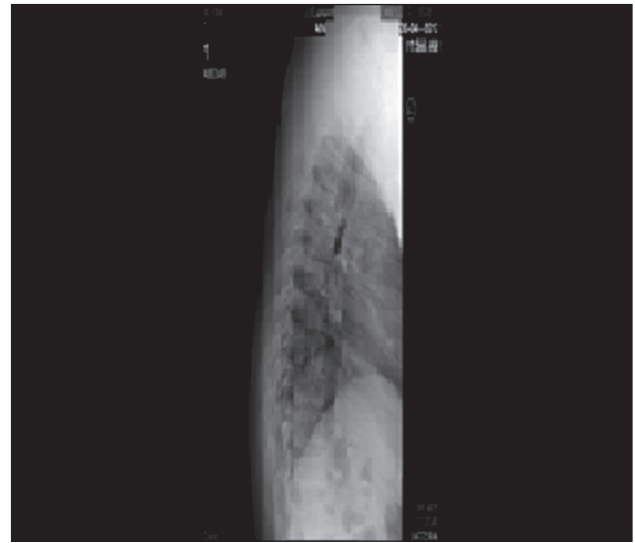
Abdomen CT scan
